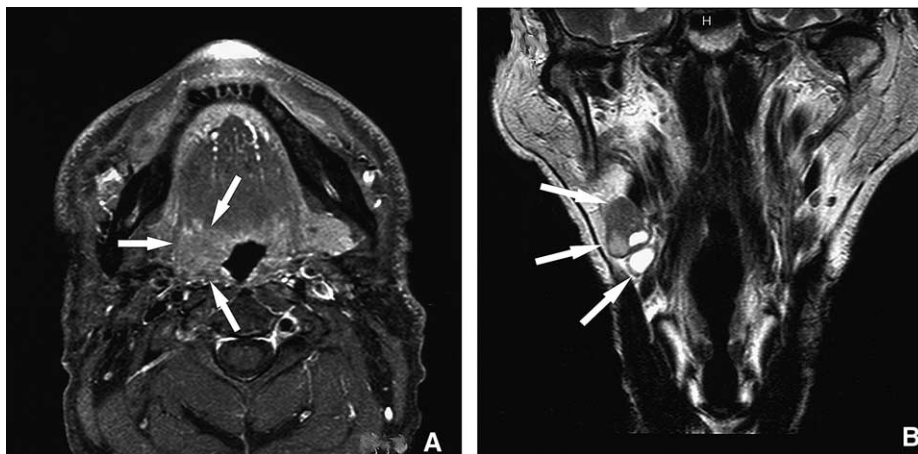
MR images of the tongue base and right neck. (A) T1-weighted sequence depicts a mass with low signal intensity at the right tongue base. (B) T2-weighted sequence shows the cystic lesions in the jugular digastric lymph nodes.
